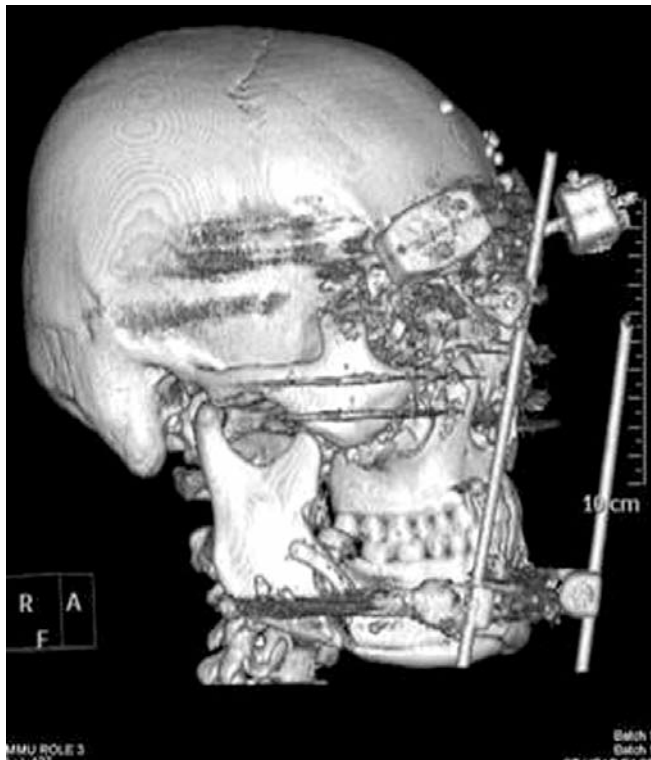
Preoperative 3D CT image showing severe ballistic complex comminuted facial fractures.
